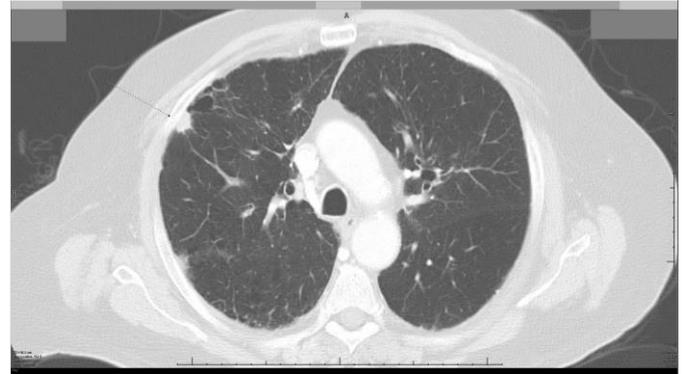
Chest CT showing a 13 mm spiculated left upper lobe nodule surrounded by significant emphysematous changes.
